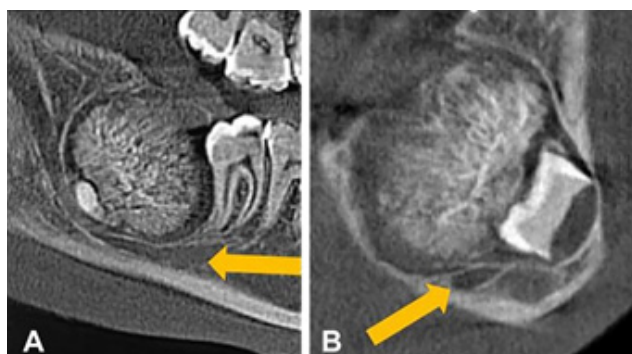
A. Sagittal and B. Coronal cone-beam computed tomography images showing the inferior displacement of the mandibular canal (yellow arrow)
